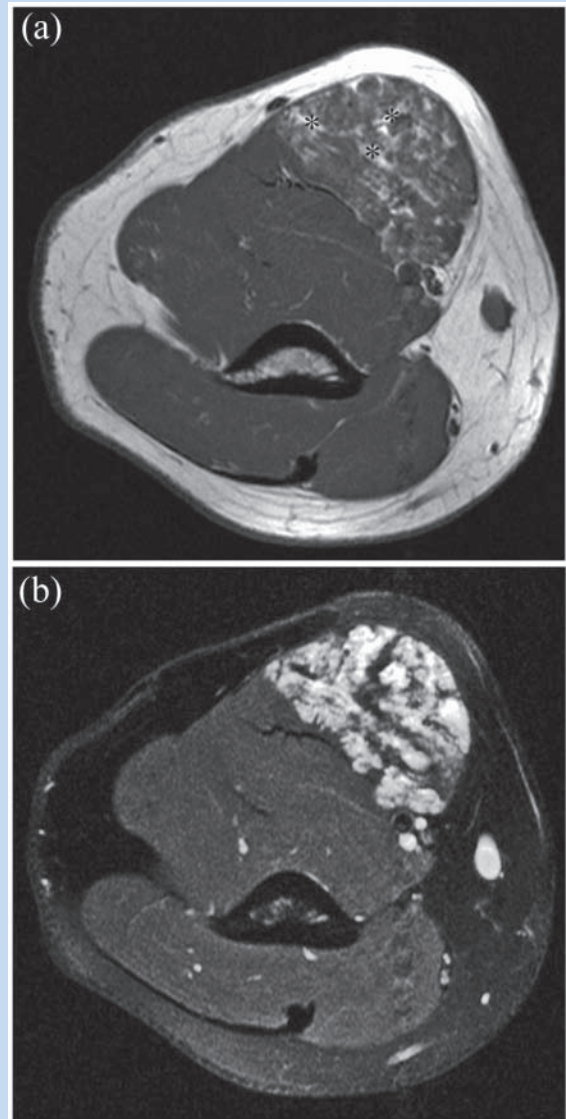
Forty-five-year-old man with a hemangioma of the right biceps brachii. (a) A T1-weighted axial magnetic resonance image through the hemangioma is very slightly hyperintense to muscle and shows multiple interlacing vascular channels of the lesion, giving a “bag of worms” appearance. High-signal intralesional fat is abundant in many hemangiomas (asterisks). (b) A STIR axial image through the hemangioma at the same level shows the vascular component of the lesion to be markedly hyperintense to muscle.
